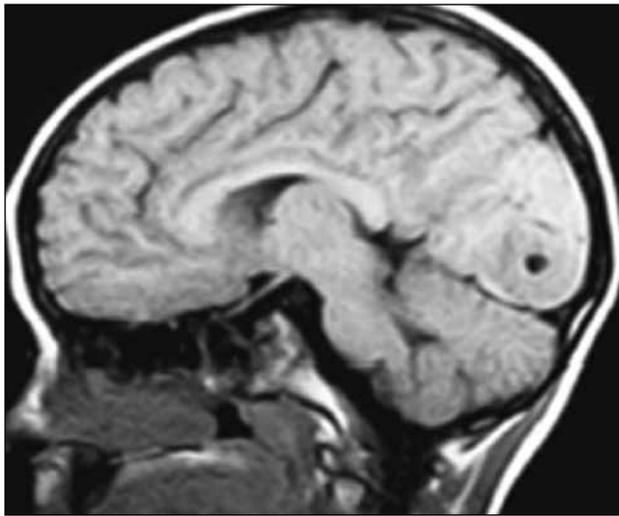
MRI-head showing an inflammatory granuloma located near the lingual gyrus of occipital lobe.
